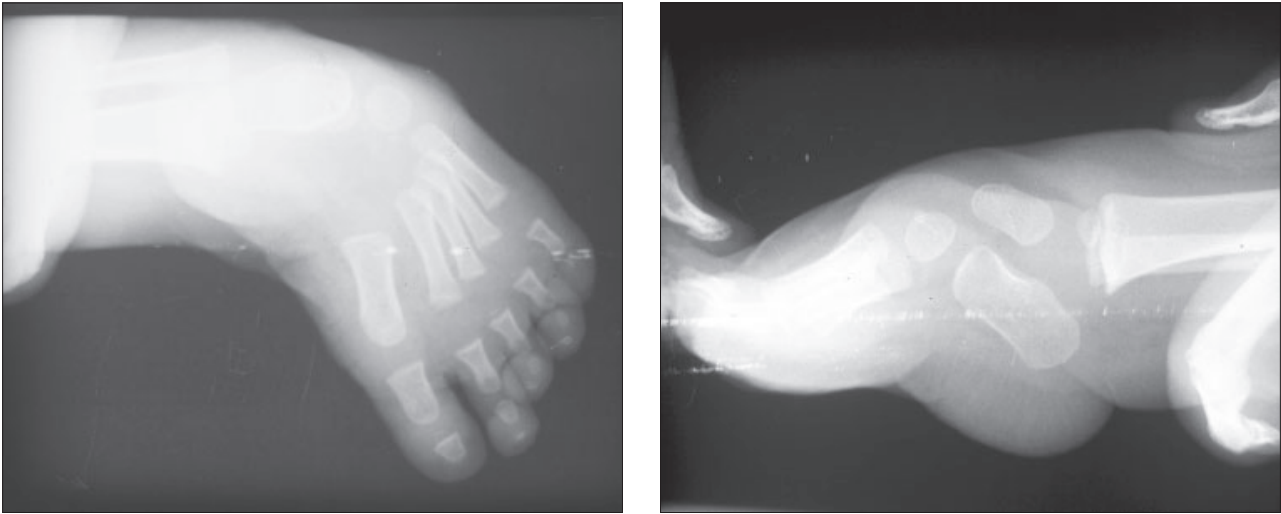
a, b. AP and lateral X-ray before the operation on the left side.
